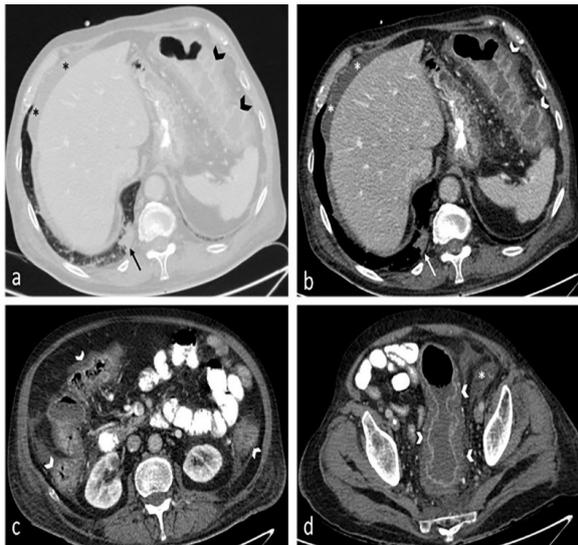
Acute pan colitis in a 74-year-old man with COVID-19 pneumonia. Axial CT images (a, b) demonstrate a subpleural patchy air space opacity (black and white arrows) at the right lower lobe suggestive of pneumonia. Axial CT images (a, b, c, d) also reveal diffuse concentric mural thickening and submucosal edema of the colon associated with adjacent pericolic fat stranding (white and black arrowheads) consistent with pan colitis. Mild free fluid is also evident in the peritoneal cavity (white and black asterisks).
